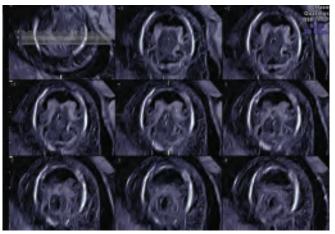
Holoprosencephaly at 12 weeks of gestation. Tomographic ultrasound imaging shows a single ventricule due to nonseparated hemispheres
